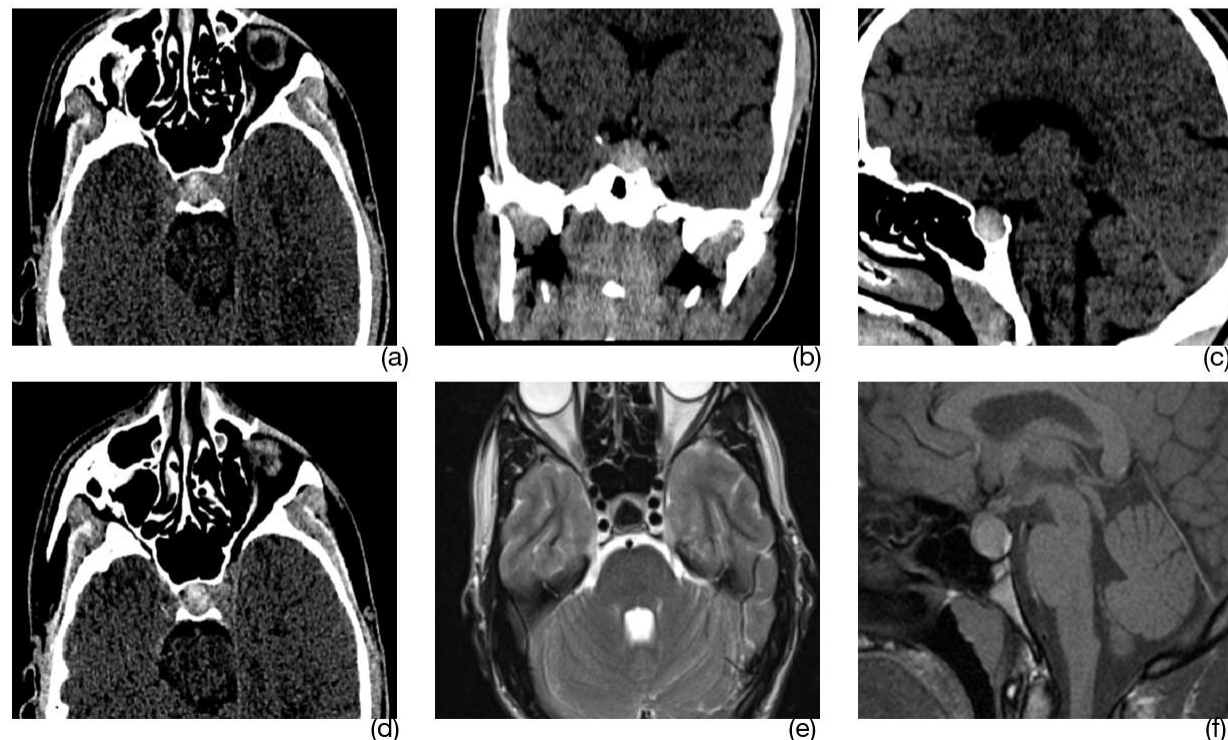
Post head trauma CT scan (a, b, c, d), MRI brain 48 hours post trauma (e, f)
